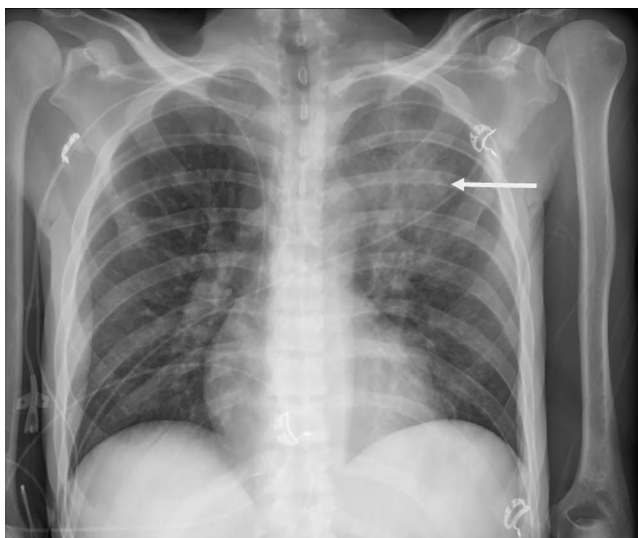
Initial chest radiograph demonstrates a left upper lobe airspace opacity (arrow), suggestive of pneumonia in this clinical context.
